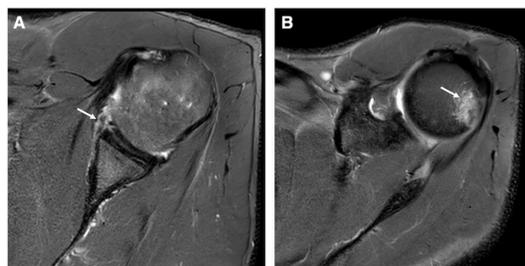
STIR axial MRI sequences (A) PDFS (Proton Density Fat Suppressed) sagittal (B) and PDFS coronal (C, D) showing full thickness tear/avulsion of long head of biceps tendon with distal retraction (arrow).
